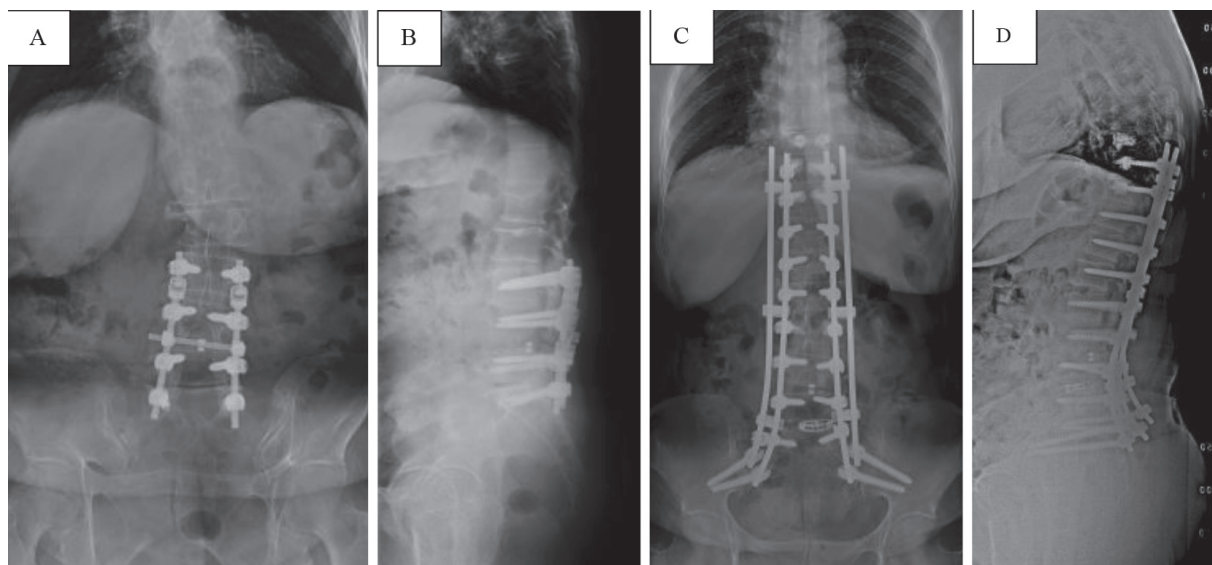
Pre-operative (A, B) and post-operative (C, D) X-rays of T10-iliac posterior instrumentation case with the use of cemented screws and vertebroplasty
